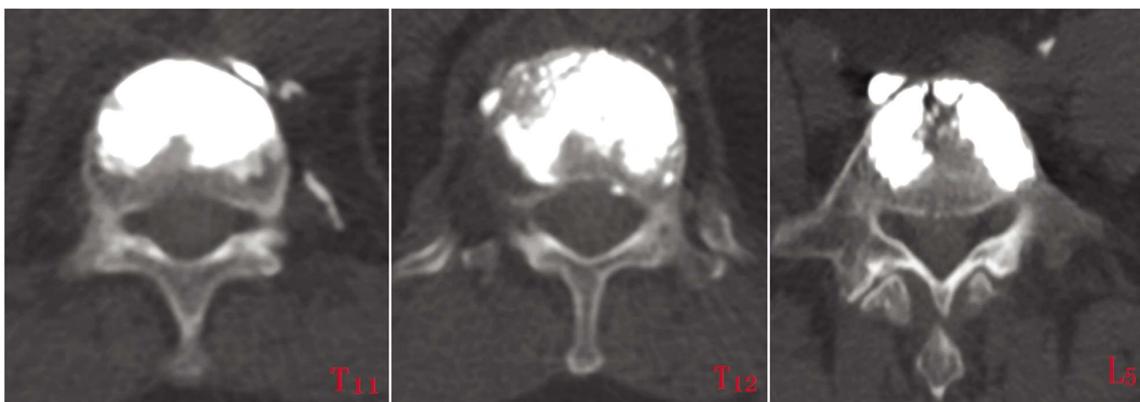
术后 T<sub>11</sub>、T<sub>12</sub>、L<sub>5</sub> CT 图
